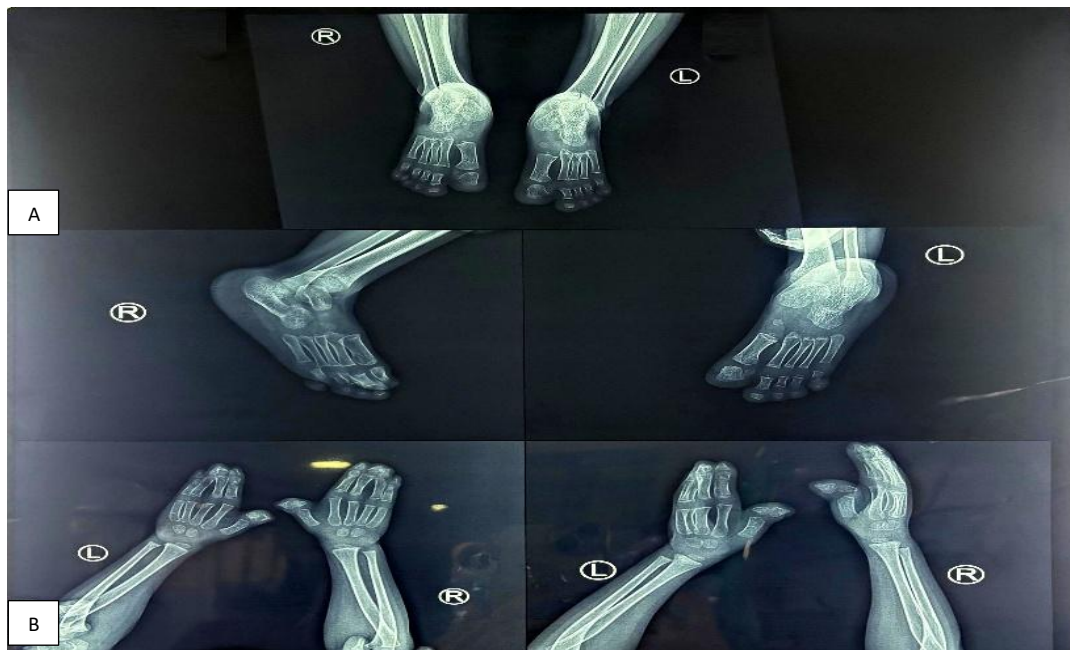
(A and B): Figure 1: X-ray of right (R) and left (L) feet showed soft tissue syndactyly and bony fusion of the toes and X-ray of right (R) and left (L) hand showed soft tissue syndactyly of second, third, fourth and fifth digits and synostosis of third, fourth and fifth digits with deformed phalanges of the first digit.
